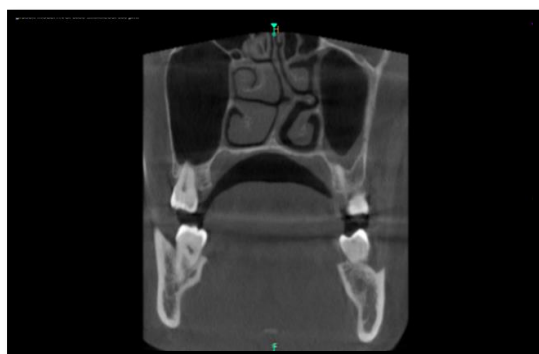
Coronal view of CBCT showing bone invasion in the superior border of left side of mandible.
